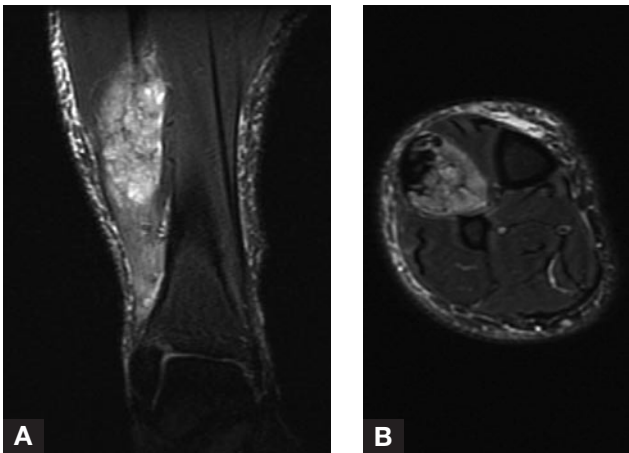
(A) Coronal and (B) axial magnetic resonance imaging of mass in right leg of 37-year-old man.
